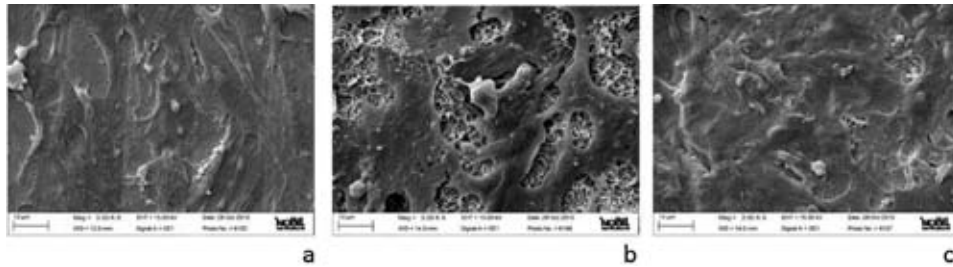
Representative SEM images (3000 $\times$ ) of SaOS2 cells after 5 days culturing on P, SA and SUV samples.
